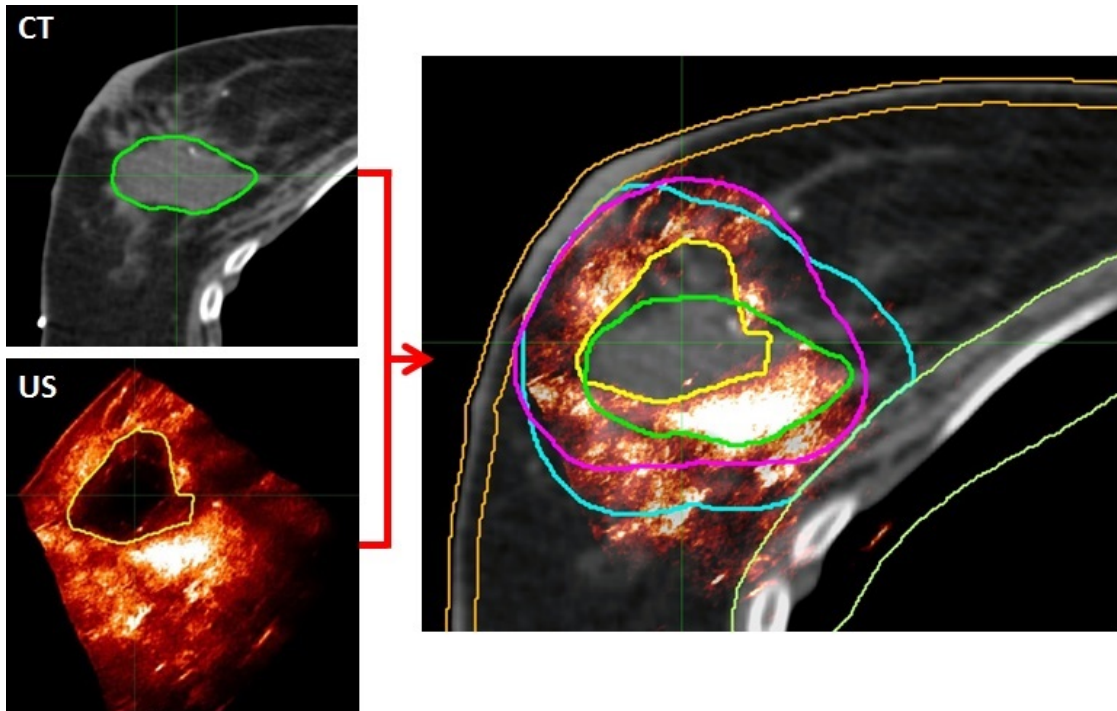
Fusion of CT and spatially registered 3DUS images. Consensus contours  $\text{CTV}_{CT}$  (green) and  $\text{CTV}_{US}$  (yellow) are expanded by 1.25 cm to create  $\text{PTV}_{CT}$  (blue) and  $\text{PTV}_{US}$  (pink), respectively, cropped to the chest wall and 5 mm from the skin surface.
